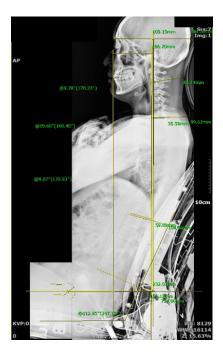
X-ray in optimal seating position (side view).
